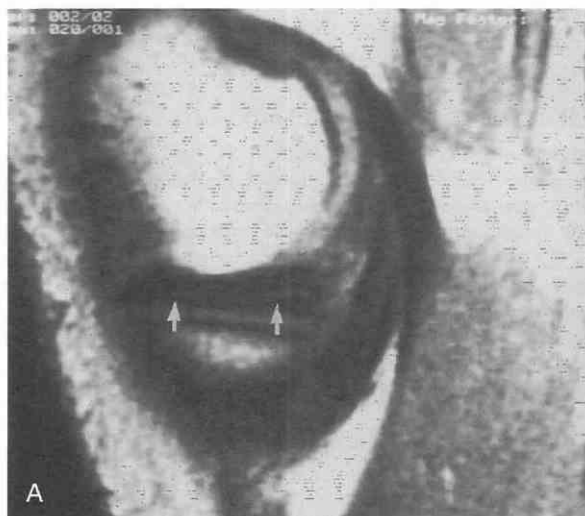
Far peripheral sagittal pseudotear. Far sagittal T1-weighted image of the medial joint compartment shows normal linear high signal intensity representing volume averaging of the joint capsule, concave surface of the meniscus periphery, and normal fat in between (arrows). This may represent truncation artifact as well.
